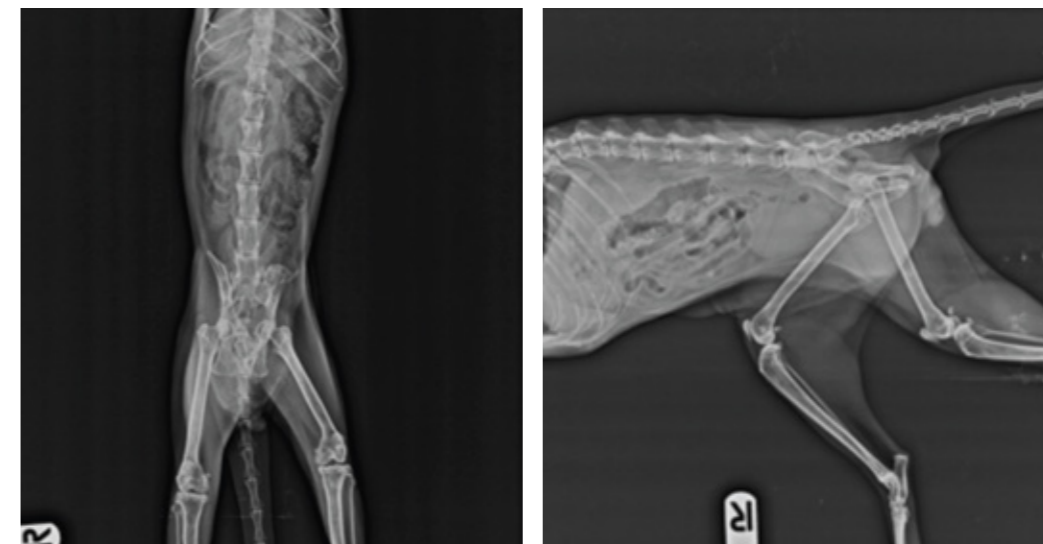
Radiographic image of week 42
